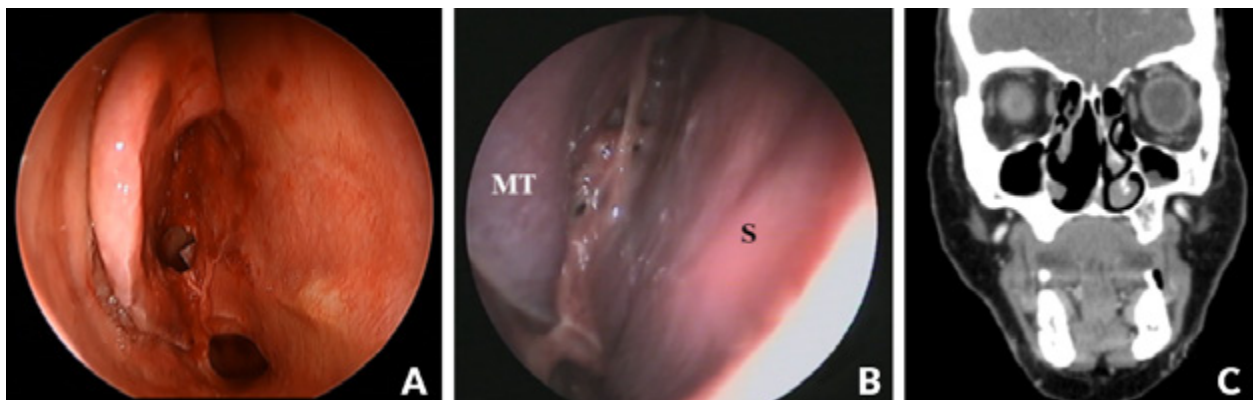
(A) After removing hemangiopericytoma; (B) Endoscopic examination without evidence of local recurrence (3-year follow-up). MT - Middle Turbinate; S- Nasal Septum; (C) CT paranasal sinuses in soft tissue window (coronal) - 3-year follow-up.
